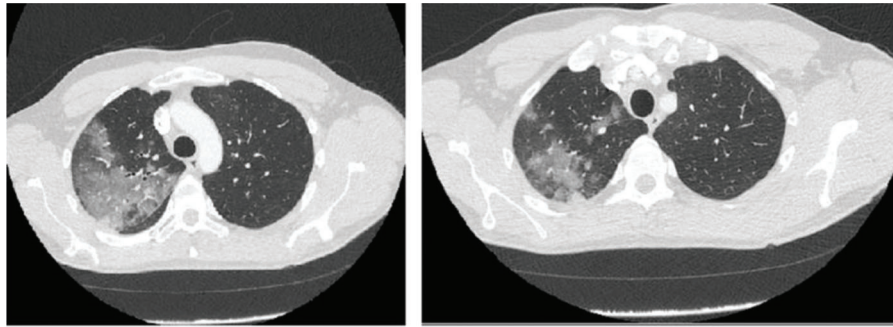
CT scan of chest reveals multifocal multilobar confluent and ground glass acinar airspace opacities along with dependent portion of right upper lobe and right middle lobe, suggestive of multifocal pneumonia.
